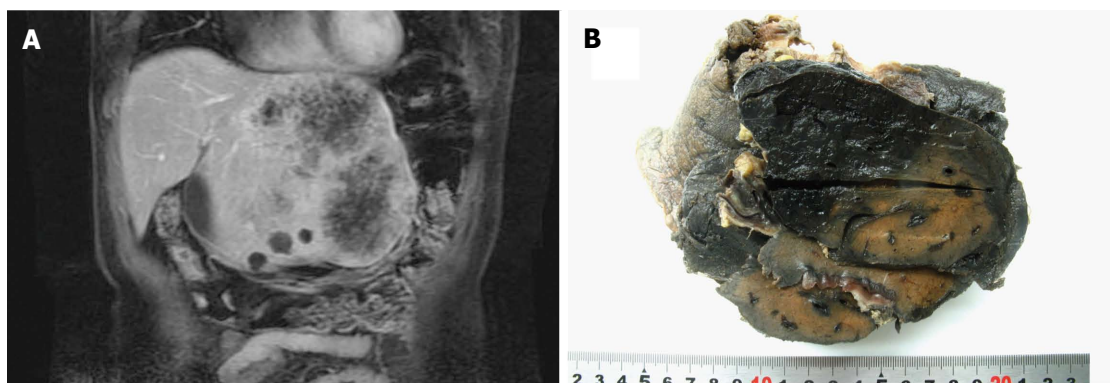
Magnetic resonance imaging and whole-mount images of hepatic angiosarcoma. A: Magnetic resonance imaging of a hepatic angiosarcoma (HAS) patient showed a significantly increased volume in the left lobe of the liver and an abnormal signal shadow with heterogeneous enhancement; B: The HAS tumor showed honeycomb morphology with an ill-defined border.
